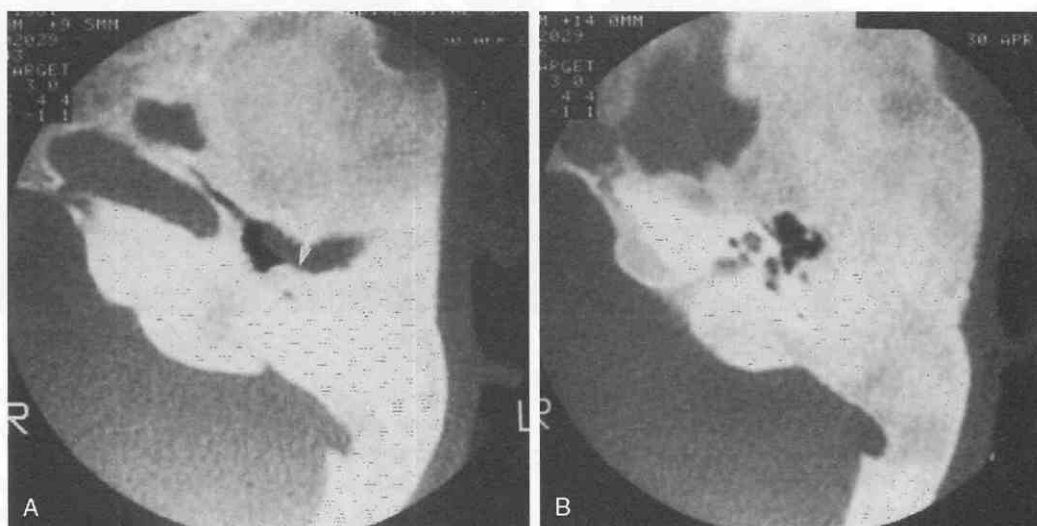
Fibrous dysplasia in a young man with a long-standing, left-sided conductive hearing loss and stenosis of the left external auditory canal (EAC). A and B, Axial CT scans of the left temporal bone show tremendous bony overgrowth, with diffuse sclerosis and thickening of the temporal bone. The labyrinthine capsule is still identifiable despite excessive new bone formation. Note the total obliteration of the mastoid air cells. The tympanic cavity is compressed, and the EAC is severely narrowed. A soft tissue mass (arrow) in the EAC represents a secondary cholesteatoma (*keratosis obturans*) caused by chronic obstruction.
